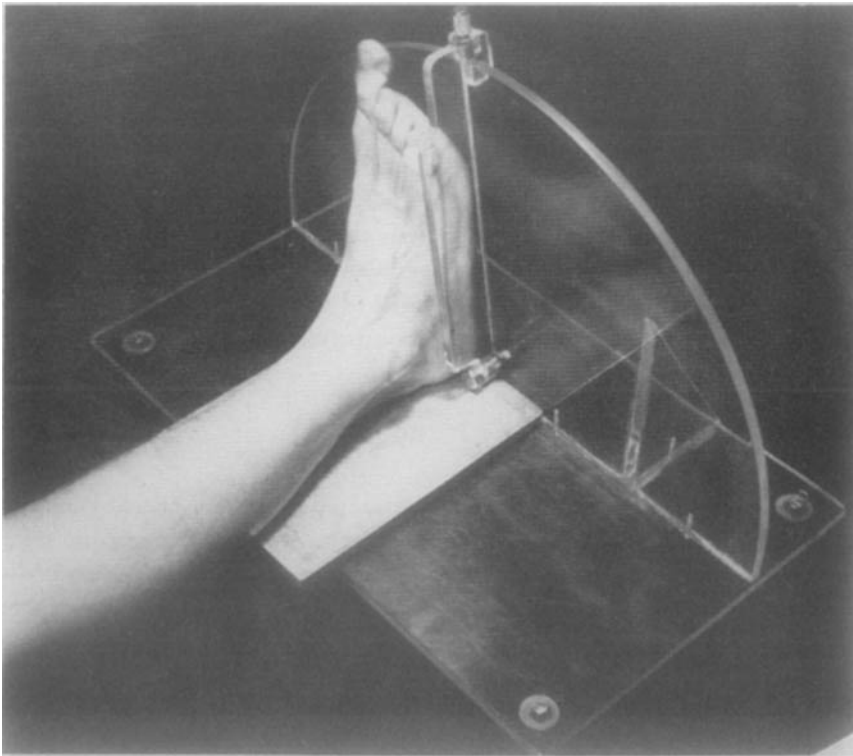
Device used in the roentgenological examination of the ankle injuries. (From Bolin, H.: *Acta radiol.* 56, 1961: Fig. 5, p. 443.)
